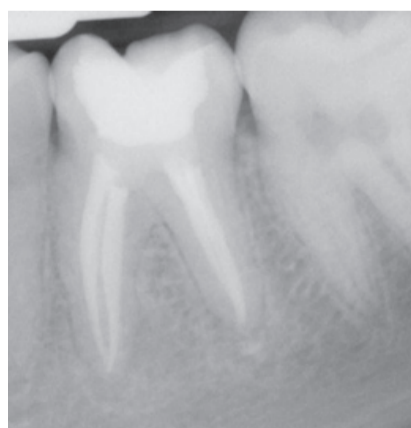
Post treatment radiograph verified obturation of all four canals to ideal length with no voids
